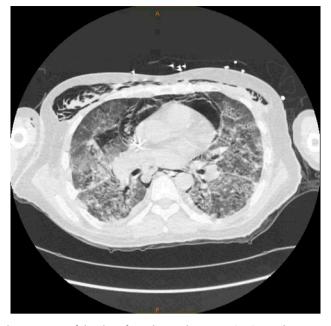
CT of the chest from day 24 demonstrating interval development of a significant pneumomediastinum, interstitial emphysema in the right middle lobe and bilateral subcutaneous emphysema, and diffuse peribronchovascular mixed attenuation nodular opacities.
